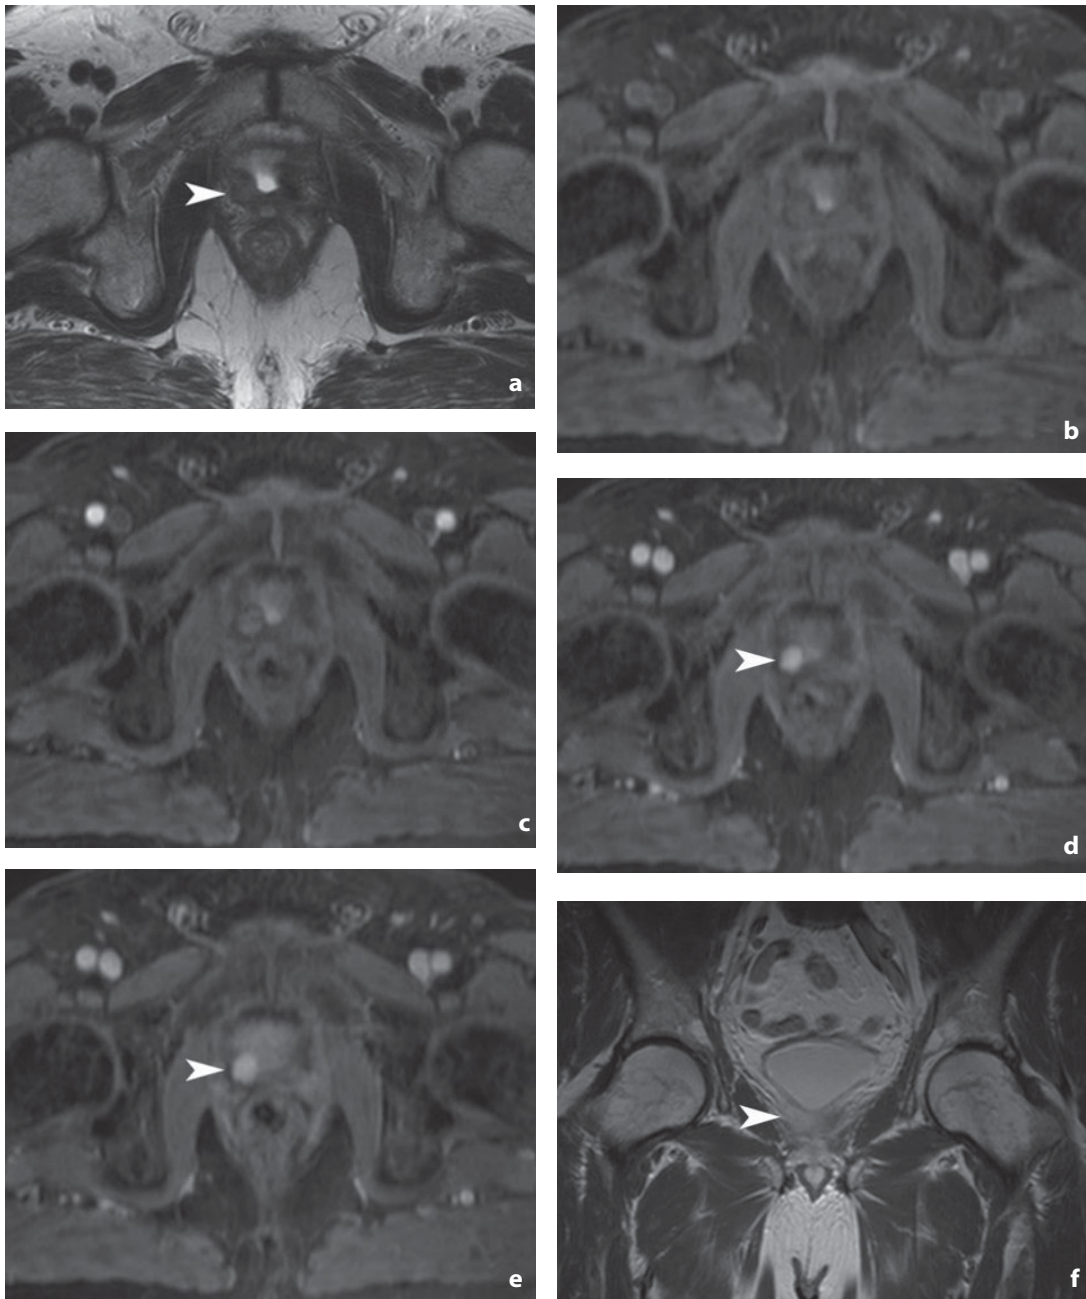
Magnetic resonance. Local recurrence after radical prostatectomy and biochemical recurrence. T2-weighted image (a) shows mild asymmetry of the vesicourethral anastomosis due to the presence on the right of a nodule (arrowhead) with intermediate signal intensity. In the venous (d) and late (e) phase of the dynamic study with paramagnetic contrast medium (b-e), the lesion appears markedly enhanced. The lesion is well visualized also in the coronal image after contrast administration (f)
